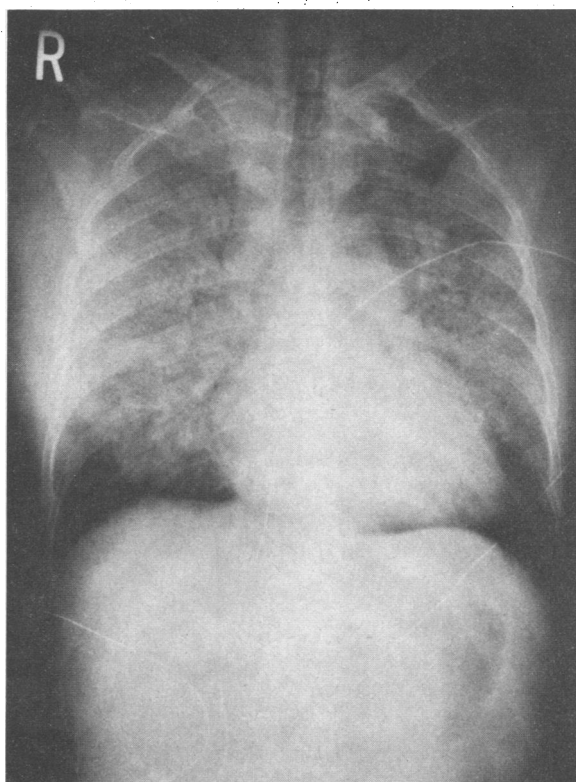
Typical x-ray appearance of ARDS in 46-year-old woman following severe hemorrhagic shock. Note bilateral alveolar infiltrates with air bronchograms.
